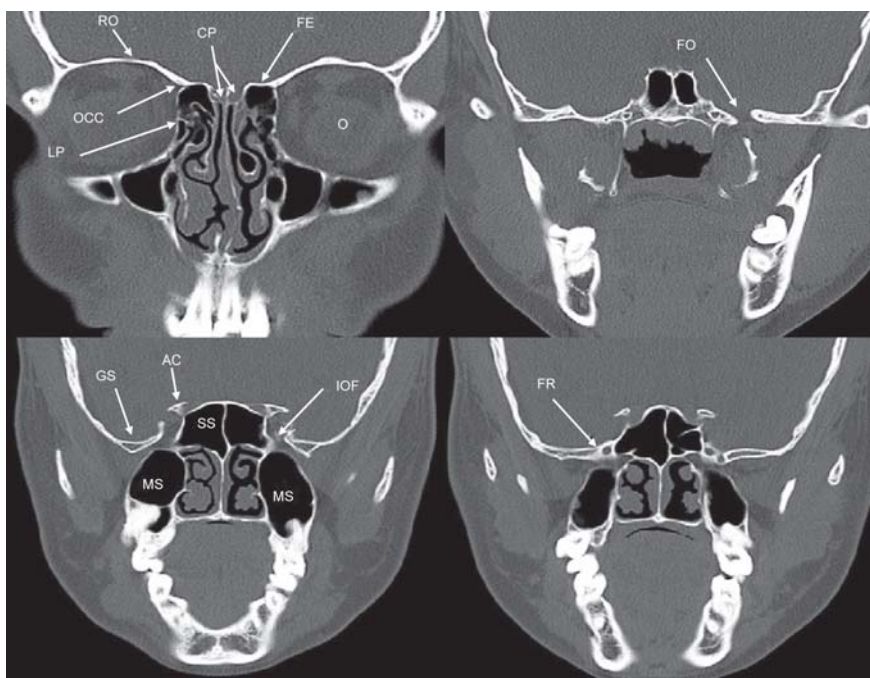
Coronal CT bone window: CP: Cribriform plate; FE: Fovea ethmoidalis; RO: Roof of orbit; O: Orbit; OCC: Orbitocranial canal; LP: Lamina papracea; GS: Greater wing of sphenoid; IOF: Inferior orbital fissure; FR: Foramen rotundum; MS: Maxillary sinus; AC: Anterior clinoid process; FO: Foramen ovale
